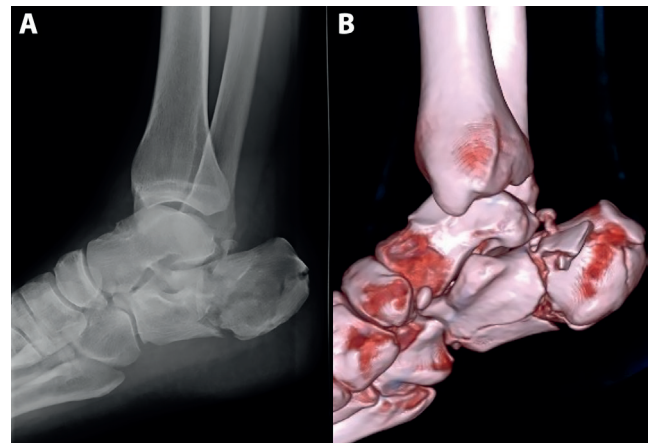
The patient before treatment on (A) lateral X-ray and (B) computed tomography (CT) scan
